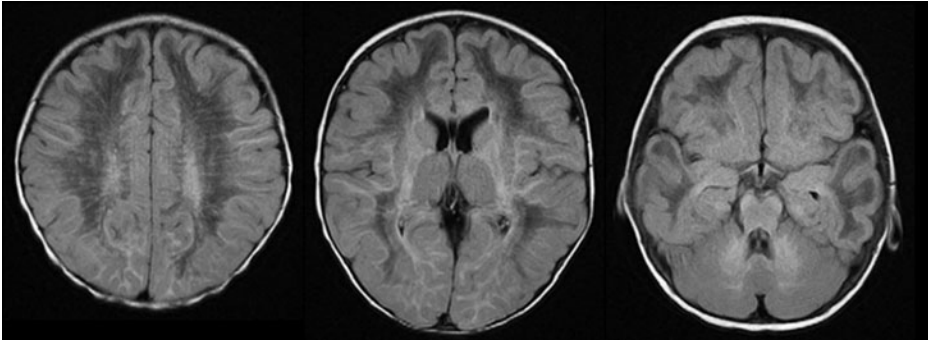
A 10 month old girl with infantile Krabbe disease. In this FLAIR sequence from a brain MRI there are T2/FLAIR hyperintense lesions in the predominantly parietooccipital periventricular and cerebellar white matter, the corticospinal tracts and the posterior corpus callosum. Grey matter structures in the basal ganglia are also involved. Courtesy of Jayne Ness, MD, PhD, The University of Alabama at Birmingham.
